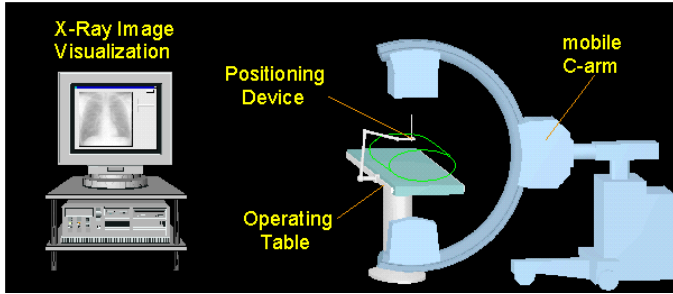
Set-up: imaging is provided by a uniplanar X-ray fluoroscope (C-arm)
